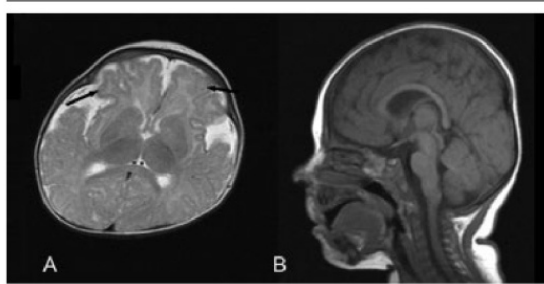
(A) T2-weighted image in the transverse plane of a 3-month-old infant with *POMT2* mutations (Patient 13). Note the predominant frontal cortical polymicrogyria (arrows) and (B) T1-weighted image showing the normal appearance of pons, brainstem, and cerebellar vermis in the sagittal plane.
